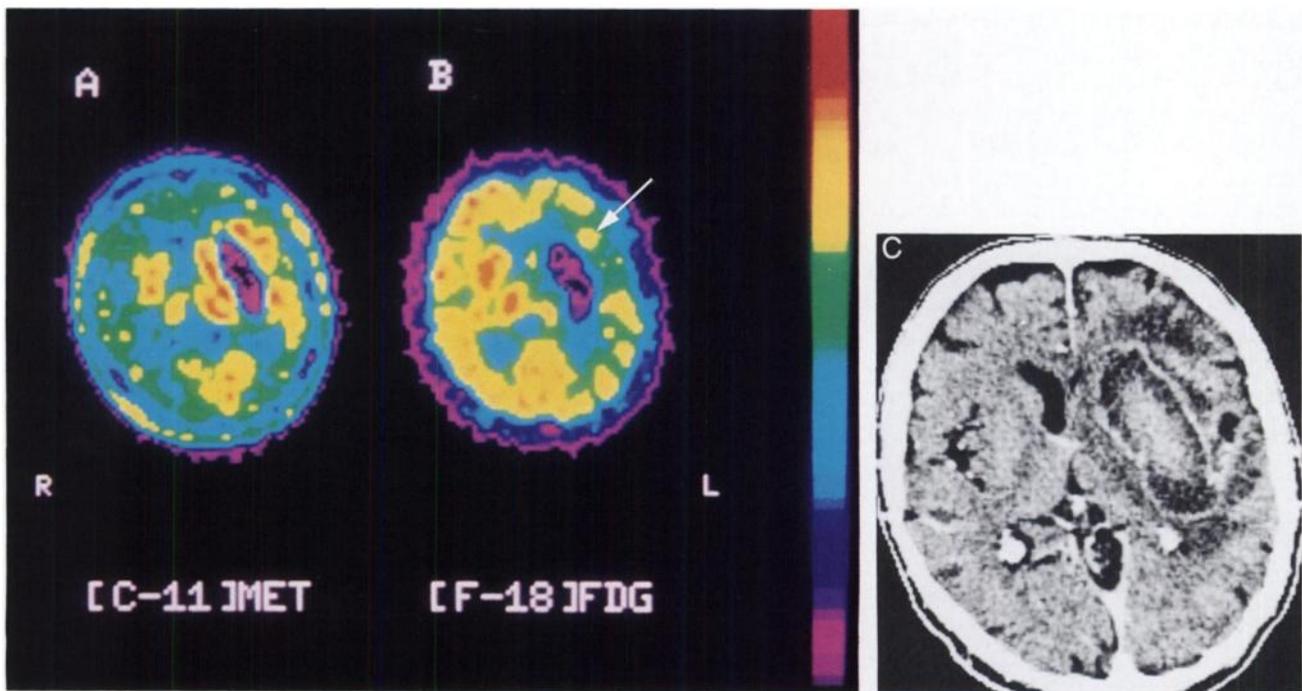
Patient 1. (A) Carbon-11-methionine PET image obtained 32 days after the hemorrhage shows high uptake of the tracer in the area surrounding the left putamino-capsular hematoma (right part of the image). (B) FDG PET image shows discrete spots of moderate uptake of the tracer next to a hypometabolic area (right part of the image). The arrow points at one spot of FDG uptake within the boundary of increased uptake of ¹¹C-methionine. (C) Contrast-enhanced CT at a level similar to the PET image shows a spontaneously hyperdense lesion surrounded by a ring-shaped zone of contrast-enhancement in the left putamino-capsular area.
